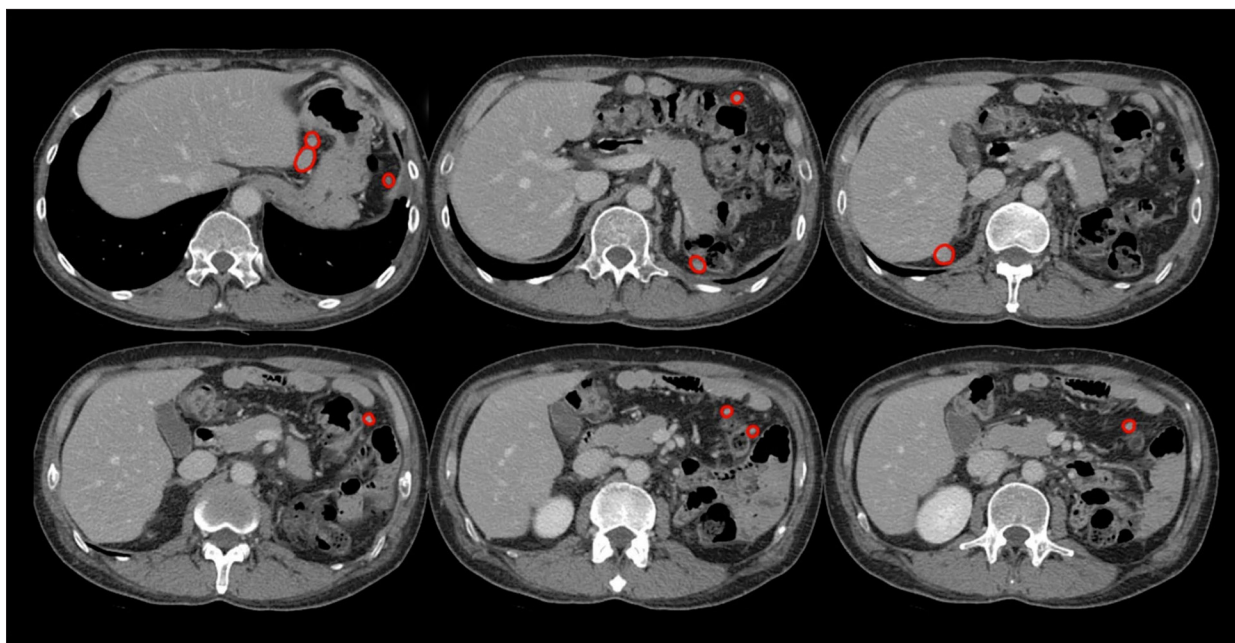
Abdominopelvic CT showing multiple soft-tissue lesions caused by the previous splenectomy. Several well-enhanced, soft-tissue lesions up to 2.6 cm in size were found in the left upper abdomen, right posterior subphrenic space, and right pelvic cavity (circled in red).
